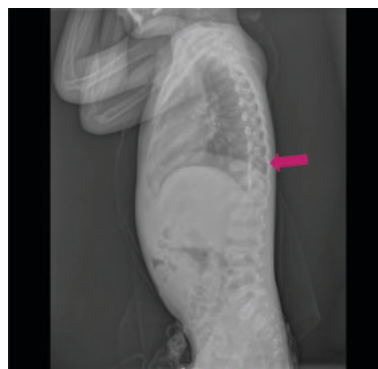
Lateral thoracolumbar radiograph showing generalized platyspondyly with flattened vertebral bodies and anterior beaking at T12–L2 (arrow indicates anterior beaking).
